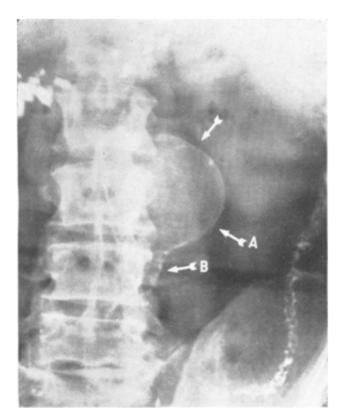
Case 1. A 24 hour gastro-intestinal roentgenogram demonstrating an abdominal aneurysm situated mesially, adjacent the 2nd and 3rd lumbar vertebra at arrows A. Note the calcification of the abdominal aorta at arrow B. The psoas muscle is clearly visible, can be seen through the sac.
